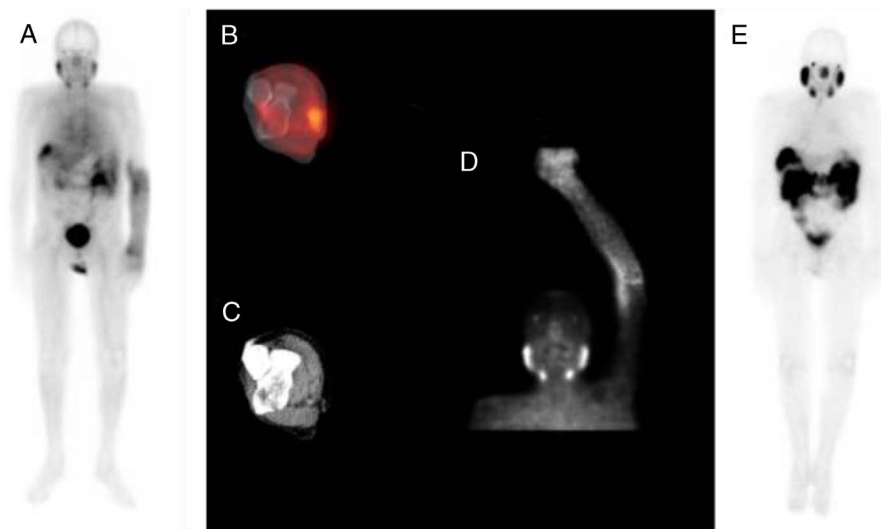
During the second cycle of radionuclide therapy, ^{177}Lu -PSMA-1 injection in the supposed left antecubital vein was difficult, and the man had a radiating pain in the hand during the first seconds of injection leading the technologists to reduce the injection rate. The 1-hour postinjection scintigraphy control of ^{177}Lu -PSMA-1 showed an intense and diffuse uptake in the left forearm with a “hot forearm” or “glove phenomenon” aspect (A, whole-body planar scintigraphy; D, static arm scintigraphy). Brachial artery’s pathway was visualized (B, axial SPECT/CT fusion; C, axial CT). It was consistent with an inadvertent intra-arterial injection, without any extravascular leakage. Peritoneal lesions were already visualized despite the early acquisition and the mistaken injection (A, whole-body planar scintigraphy). The arm was elevated and massaged. The 24-hour postinjection scintigraphy demonstrated a very intense ^{177}Lu -PSMA-1 uptake by the peritoneal lesions, and a full removal of the intra-arterial injection (E, whole-body planar scintigraphy). The man did not experience any pain or redness in the forearm afterward. The left hand arm estimated that the absorbed dose obtained by Monte Carlo calculation¹ was 0.09 mGy/MBq, 20% higher than the controlateral arm. Inadvertent intra-arterial injection has already been described with different diagnostic radiopharmaceuticals, such as $^{99\text{m}}\text{Tc}$ -MDP,^{2,3} $^{99\text{m}}\text{Tc}$ -MIBI,⁴ ^{123}I -MIBG,⁵ or ^{18}F -FDG,^{6,7} without any serious interferences or adverse events. To our knowledge, radionuclide therapy (ie, ^{177}Lu -PSMA-1) intra-arterial injection has never been described yet. Venipuncture can be challenging in patients followed up for cancers because of fragile venous network caused by multiple venous access, especially in elderly patients. Injection requires careful attention to the color and blood return movement, notably catheter’s pulsation. Correct catheter placement and insertion practices were highlighted. At cycle 3, man demonstrated an excellent biological response with an 85% decrease PSMA rate (PSMA rate dropping from 608 to 89 ng/mL), a decrease in lesions uptake on scintigraphy, and an OR on the CT component of the control SPECT/CT. This case demonstrated the lack of repercussion of inadvertent intra-arterial ^{177}Lu -PSMA-1 injection on patient’s response to therapy, but the person in charge of the radionuclide therapy injection should be aware of this potential risk.
